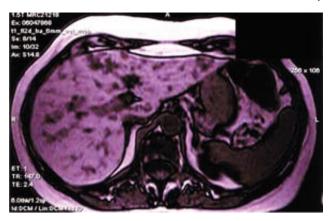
Magnetic resonance imaging showing multiple enhancing liver lesions suggestive of metastatic liver disease.
